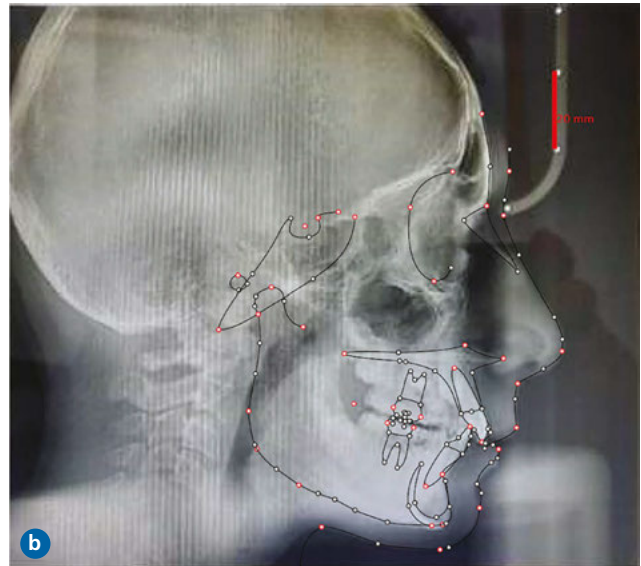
2B Pre-treatment x-ray records.
